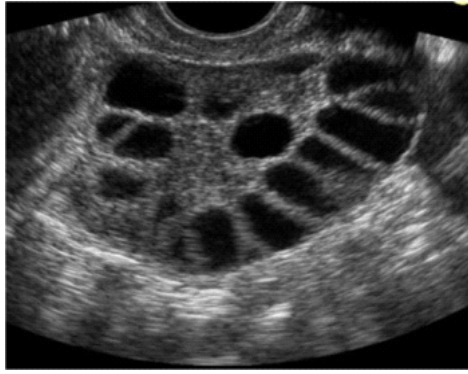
Ultrasound Image of PCOD (Rumak,c.et al 2011)
